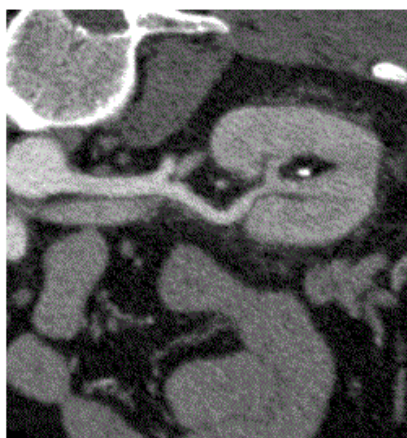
Reperfusion after 7 days on follow-up CT angiography.
